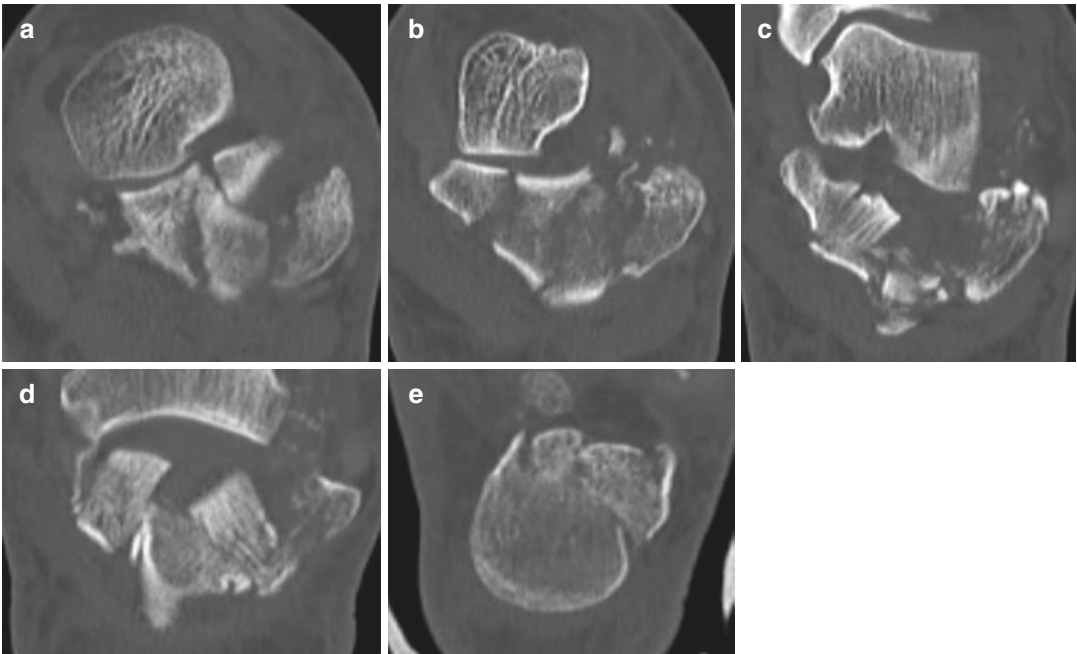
Coronal CT images
